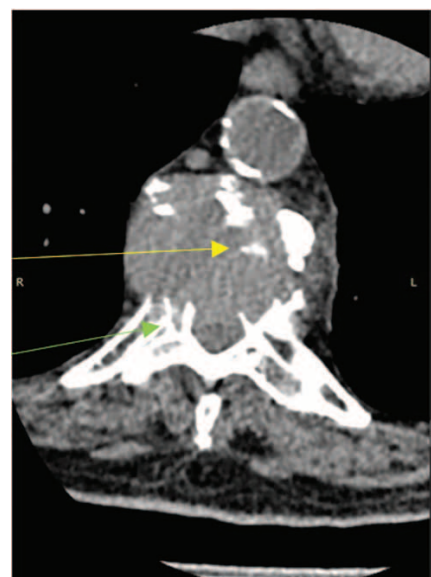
CT, axial slice. Destruction in the vertebral body and pedicles, as well as the posterior wall of the vertebral body
